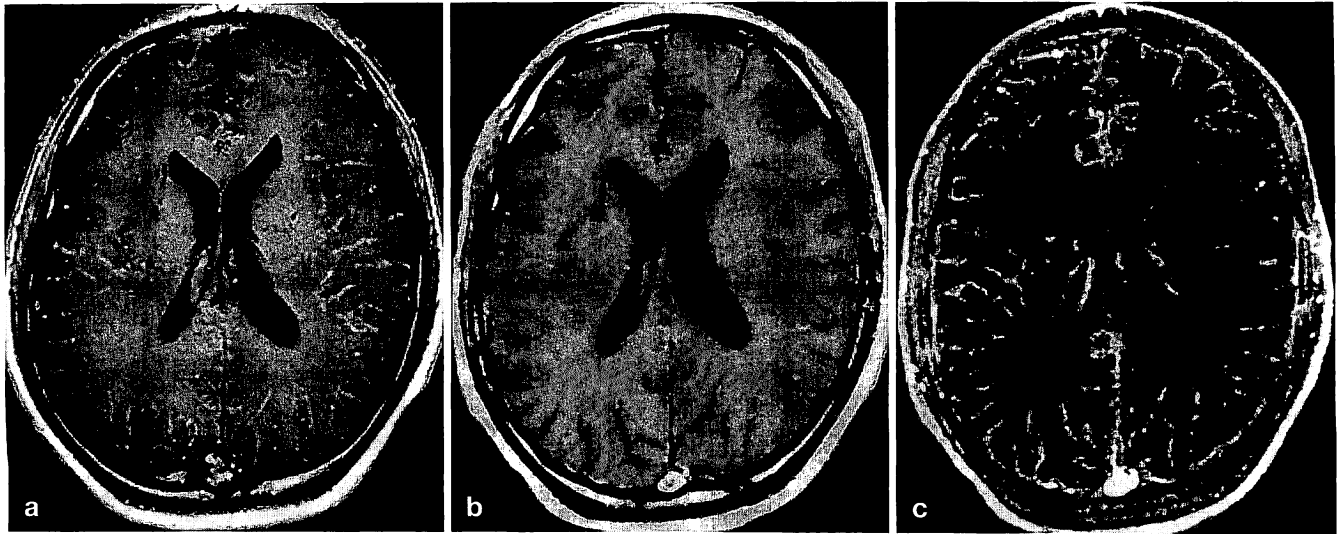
a–c Patient 5 developed a transient ischaemic attack with alternate hemiparesis several times when singing loudly during the 2 years preceding preoperative MRI. Superficial temporal–middle cerebral artery anastomoses were performed bilaterally. MRI was repeated 1 year after surgery. LMCE over the cerebrum is marked preoperatively (a) but after bypass surgery (b) it becomes moderate, while a subtracted image shows it more clearly (c)
